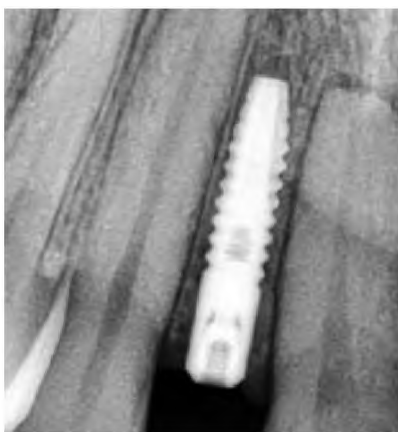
X-ray control for 3 months after surgery.
